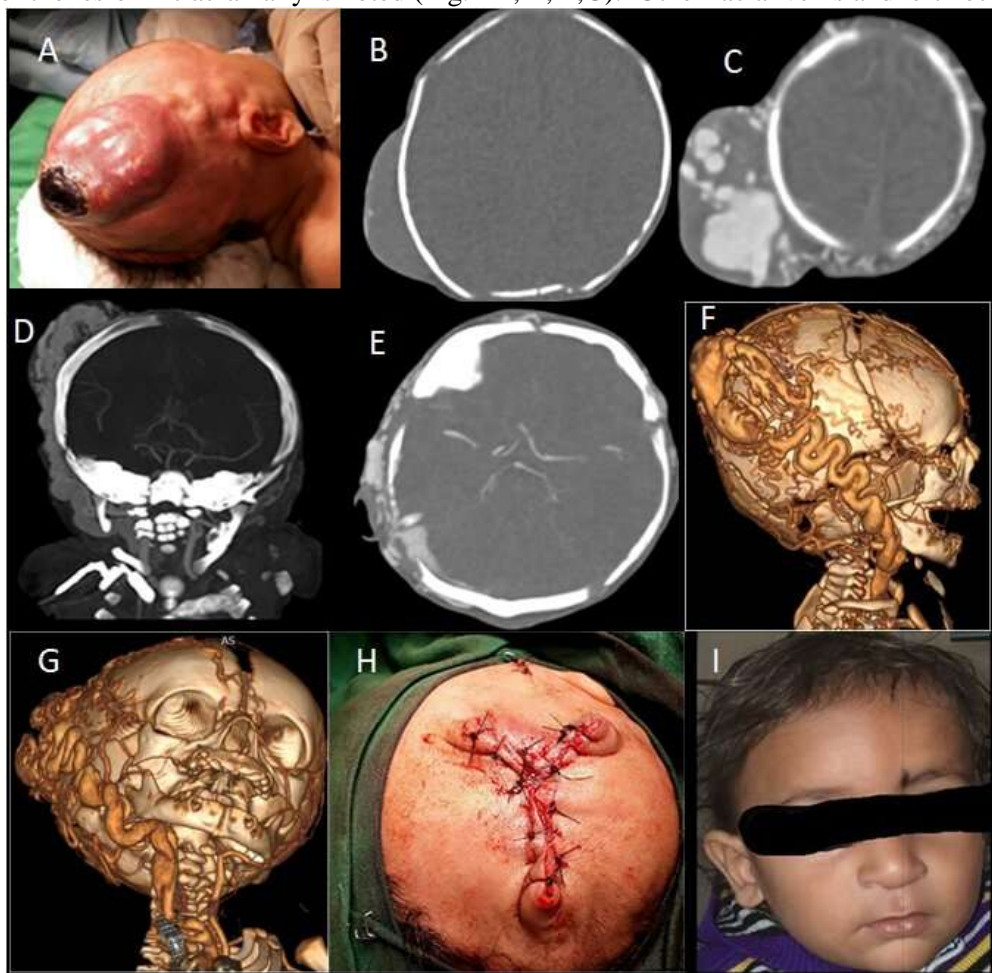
(A) Showing Neonate with ~6x7cm right scalp swelling with focal discoloration and skin thinning. (B) NCCT showing few hyperdense foci suggestive of calcifications in the periphery of a large hypodense scalp lesion. (C, D) CTA showing scalp lesion with dilated and tortuous vascular channels, dilated and tortuous right retromandibular and common facial vein, prominent right CCA and superficial temporal artery with (E) early draining veins on the arterial phase causing opacification of right sigmoid sinus and right transverse sinus and (F and G) VRT images showing the same findings. (H) Post op picture showing single layer-interrupted sutures. (I) Follow up at two years of age. No recurrence.
